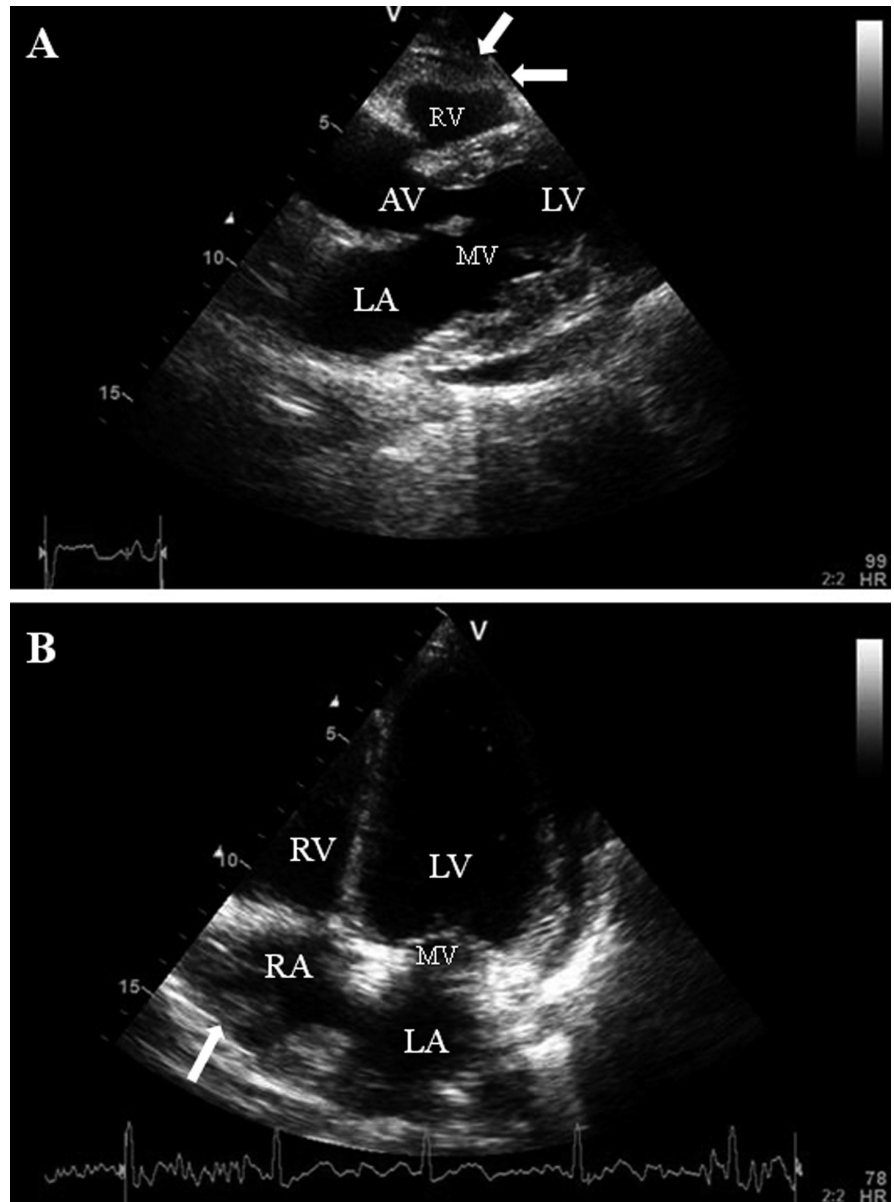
Echocardiography (parasternal view and 4-chamber view) showing mild to moderate pericardial effusion (arrowhead). Note the diastolic collapse of the free wall of the right ventricle (parasternal view, arrow) and the paradoxical movement of the right atrial free wall (4-chamber view, arrow).
